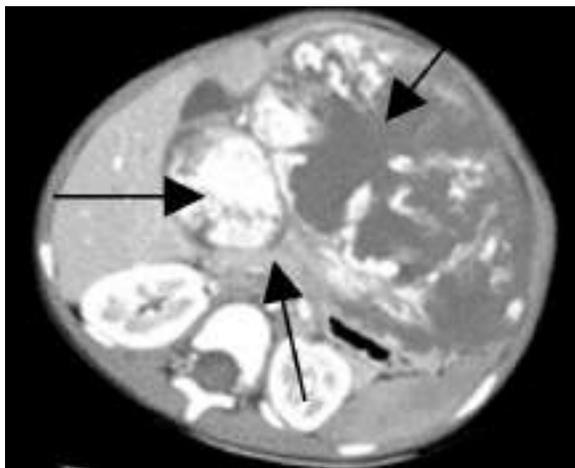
CT Abdomen (Black Arrows:Hemangioma)
